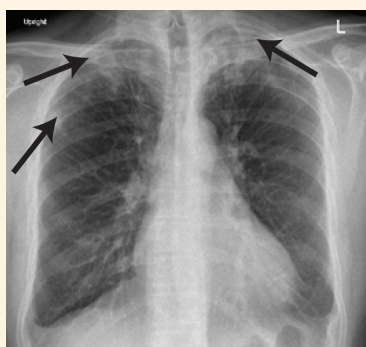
Chest X-ray of a 39-year-old male patient showing bilateral upper lung zone airspace opacities (arrows).
